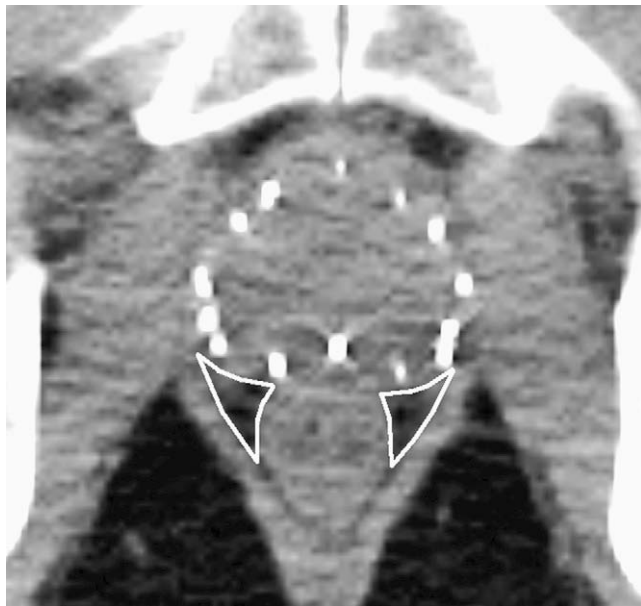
Right and left neurovascular bundle structures (outlined above) were identified on axial computed tomography as triangular structures bounded by the posterolateral edge of the prostate, the levator ani muscle, and the rectal wall.
